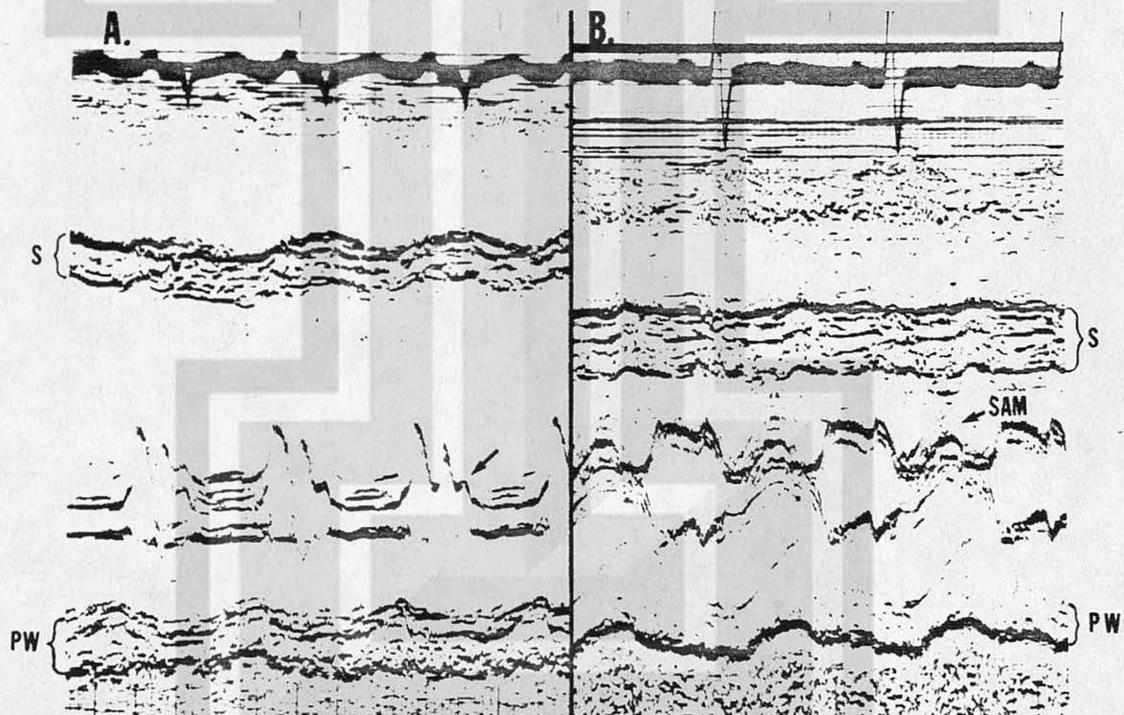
Echocardiograms.
